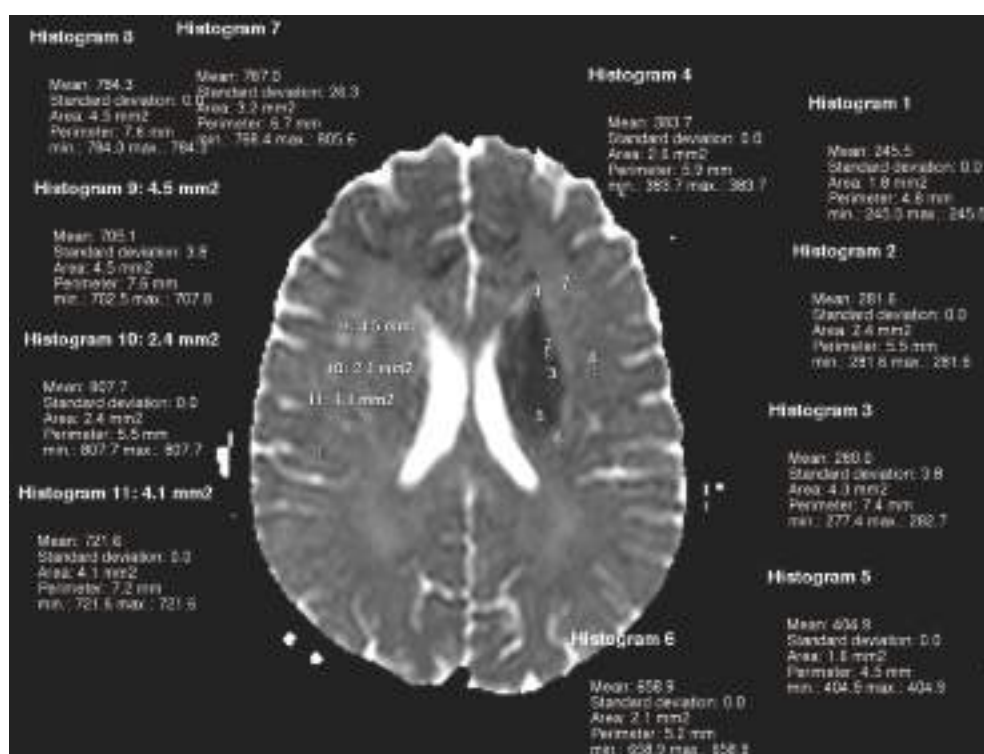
Sample of an MRI for examining the brain among AD patients. MRI, magnetic resonance imaging; AD, Alzheimer's disease.
